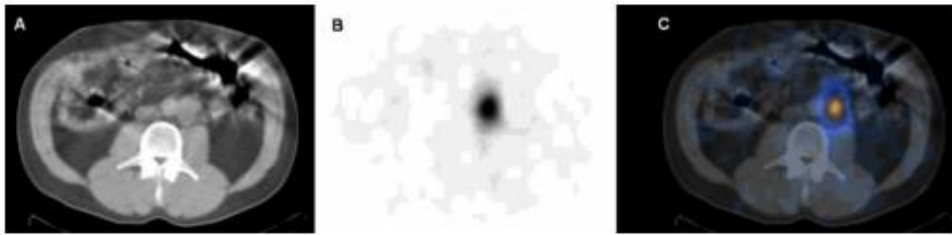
Detection of liver abnormalities using CT (on the left), SPECT (on the middle) and fused SPECT/CT (on the right) [25].
